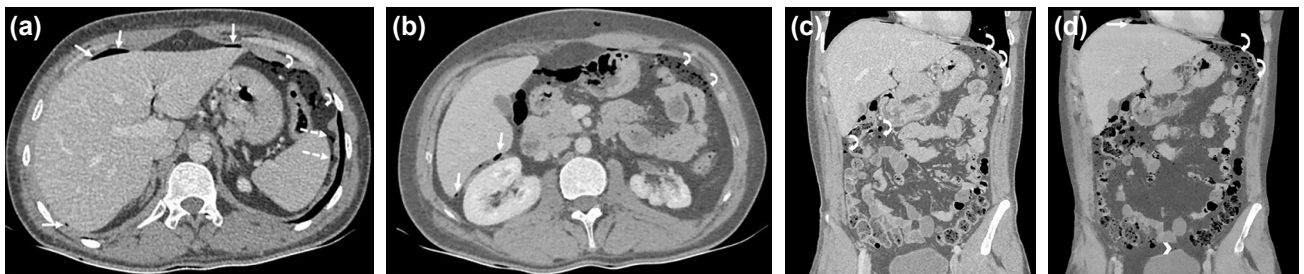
Axial (a) axial reformatted minimum intensity projection (MinIP) (b), coronal (c), and coronal reformatted MinIP (d) contrast-enhanced abdominal computed tomography (CT) revealed millimeter-sized air bubbles in the perihepatic (long white arrows) and perisplenic (dashed white arrow) regions, and fatty tissue between intestinal segments (curved white arrows). Air bubbles were also detected in the retroperitoneal region and around the bladder (arrowhead), accompanied by fatty tissue heterogeneity.
